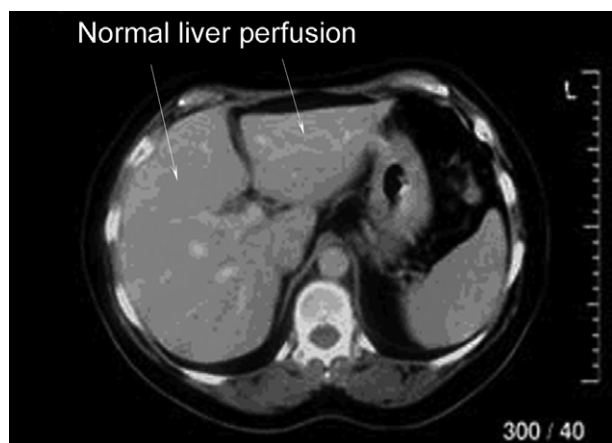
Pre-contrast CT showing normal liver.
